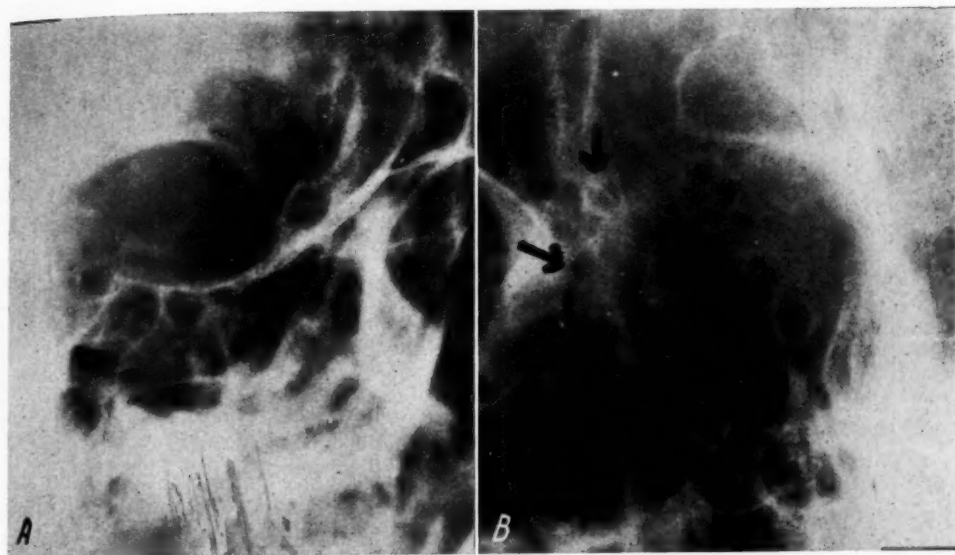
(Spackman). A, X-ray projection of a normal orbit. Note that the trabecular structure of the ethmoid cells shows through the inner wall of the orbit. B, there is increased density of the osseous structure of the inner orbital wall due to localized osteitis.
